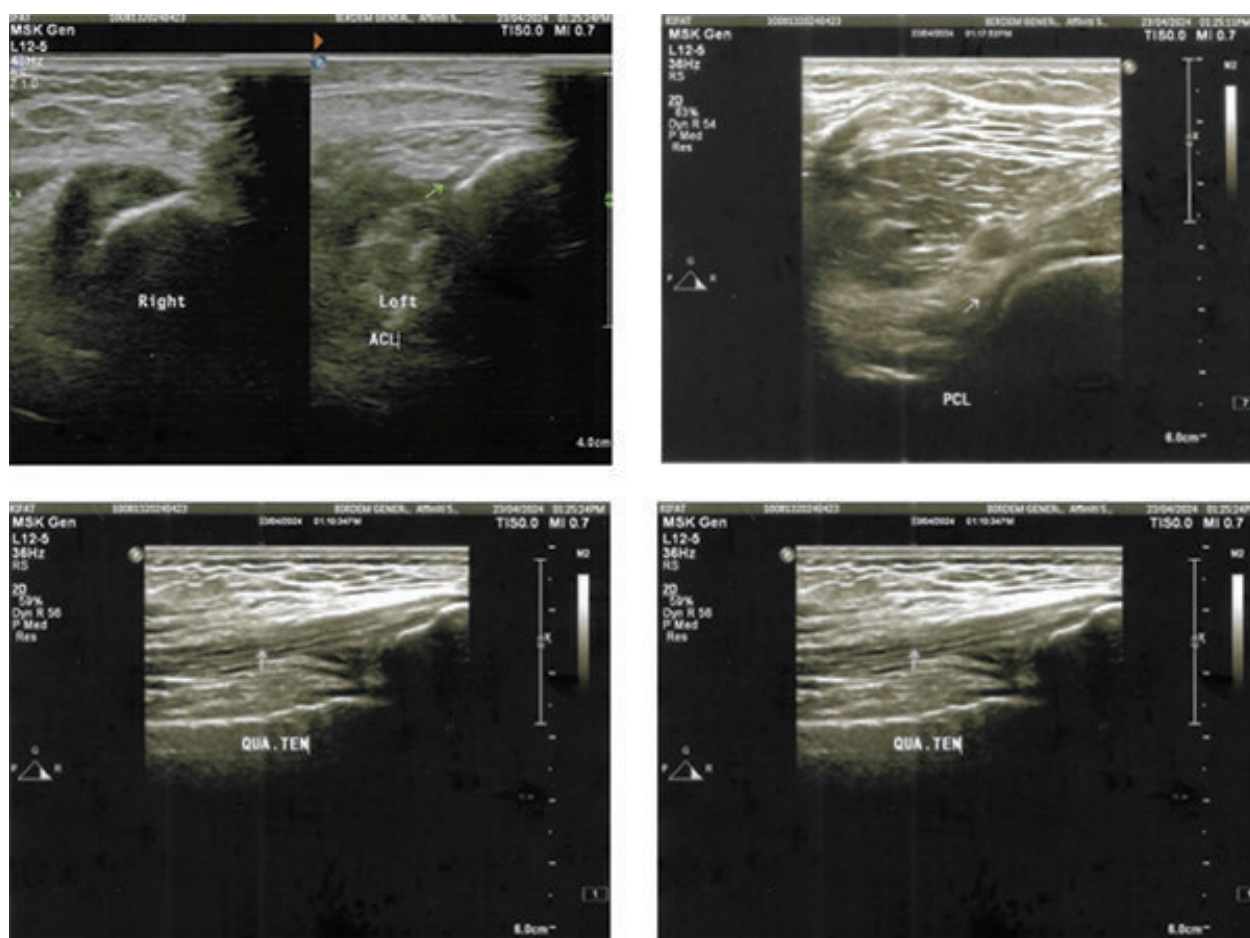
Ultrasonogram of right knee joint of a 26 years old male patient showing anterior cruciate ligament (ACL) is swollen. Minimal anechoic fluid collection around right knee joint.
